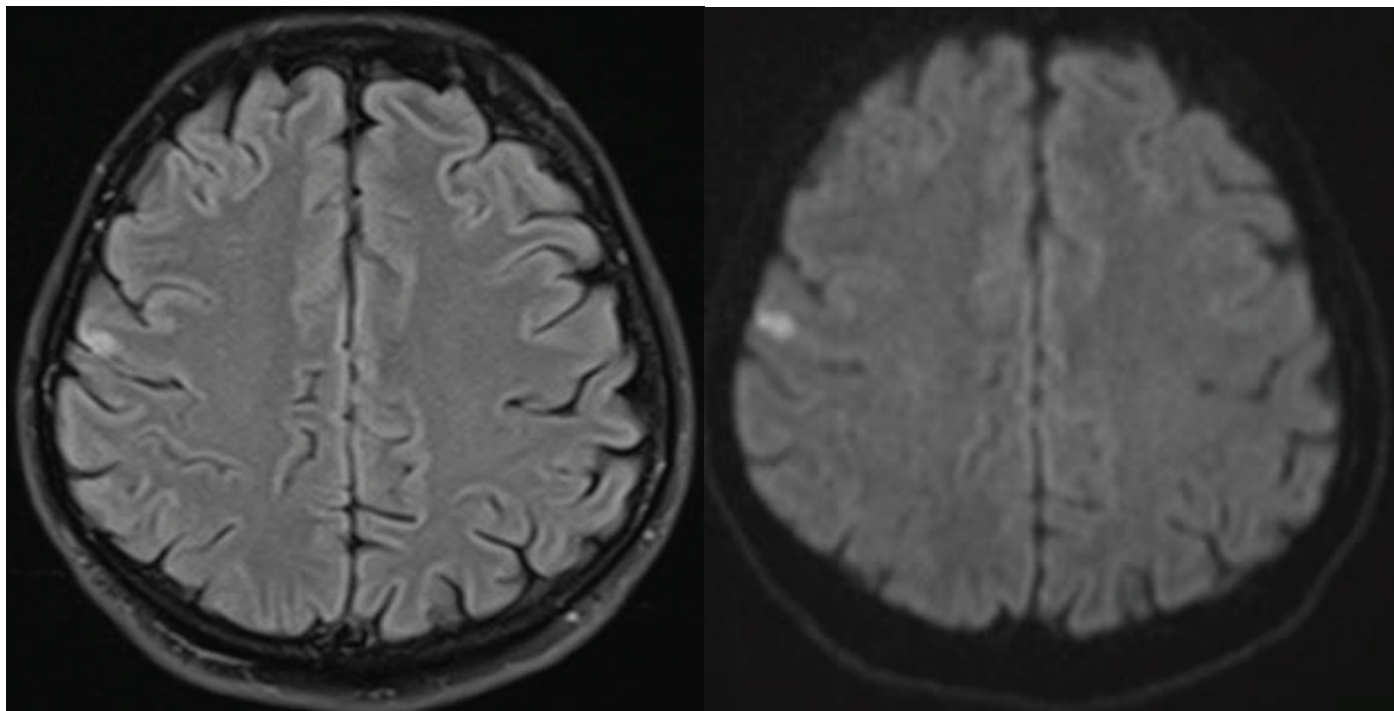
Initial MRI of the brain, showing an infarction in the right precentral gyrus.
